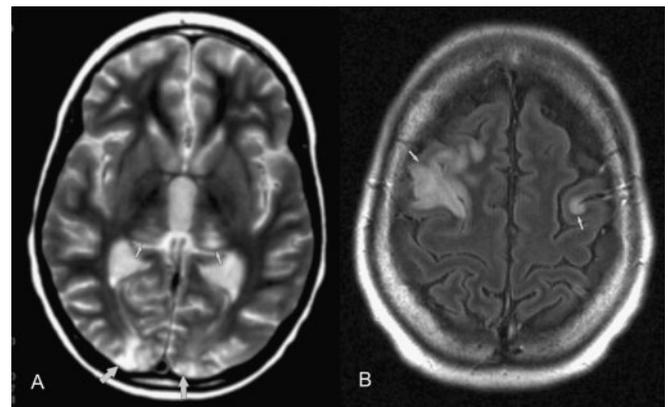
(A) Axial T2-weighted MRI showing high signal lesions in the thalami (small arrows) and occipital cortices (large arrows). (B) Axial FLAIR MRI showing high signal intensity changes in the frontal cortex bilaterally (arrows) in a patient with focal motor status epilepticus.
